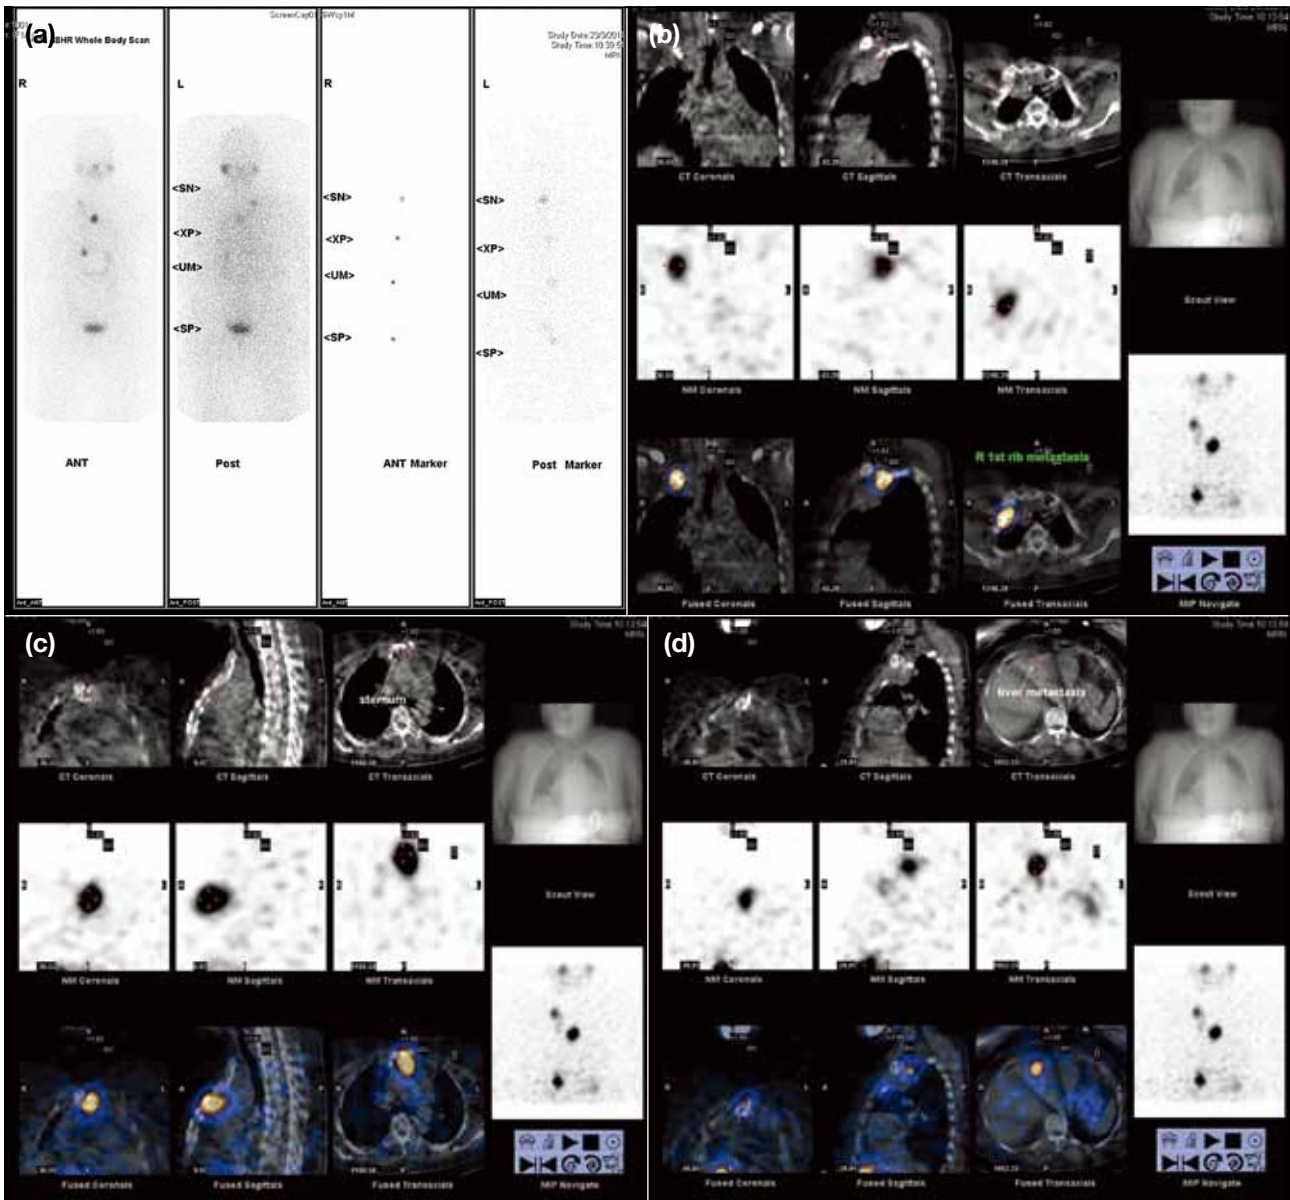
(a) Low-dose diagnostic ^{131}I (111 MBq) whole-body biplanar scans for evaluation of metastatic disease show abnormal uptake in the chest and abdomen. (b to d) SPECT/CT fusion images show metastases in the right first rib end, sternum, and left lobe of the liver, respectively.
